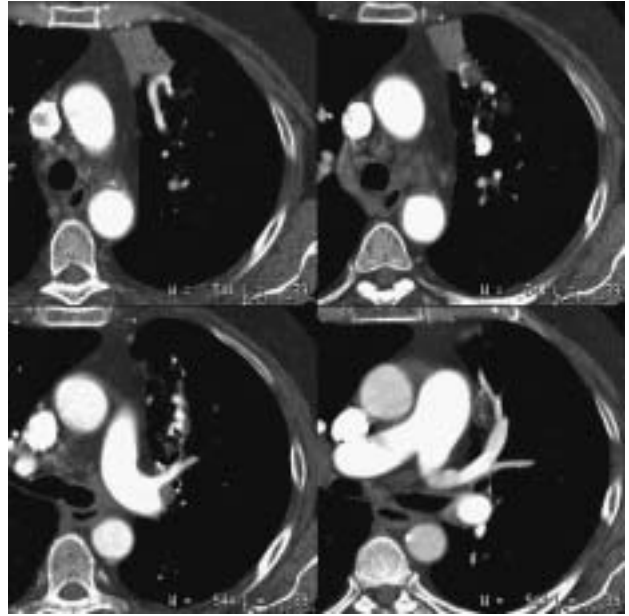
Four slices of contrast-enhanced spiral computed tomographic acquisition through the left upper lobe showing tortuous vessels within the anterior segment.
